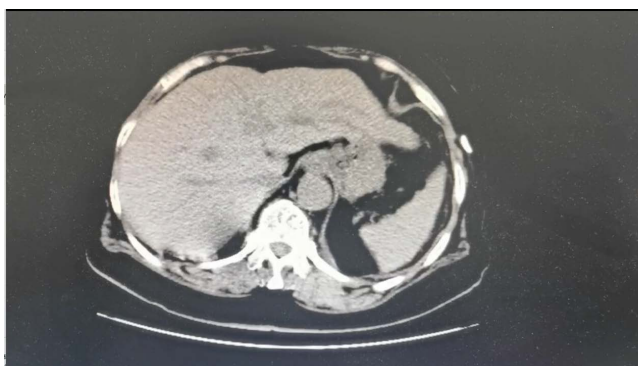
Postoperative CT images: the lesion in the S2 segment has significantly reduced in size.
